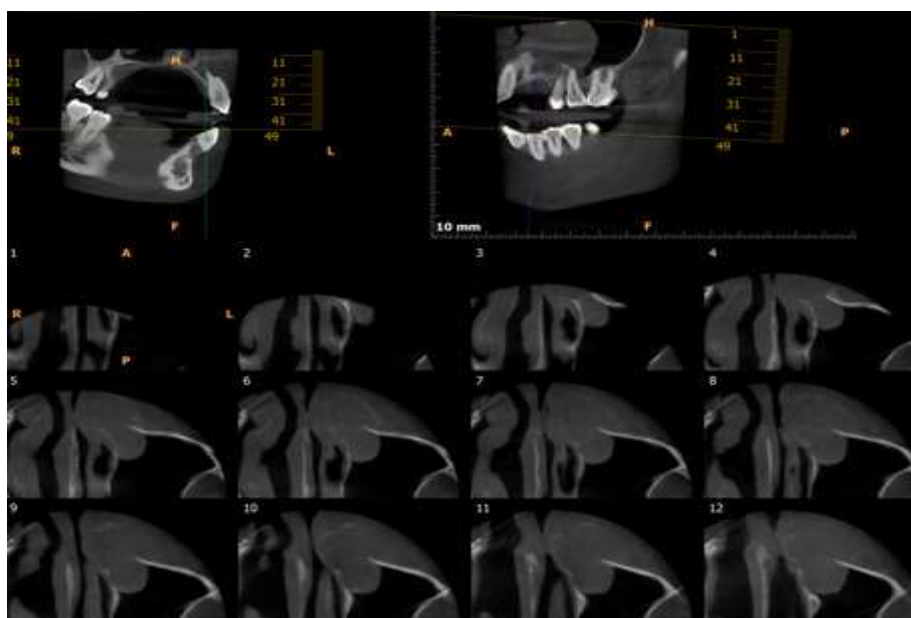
B: CBCT confirmed focal destruction in anterior region of maxilla.
